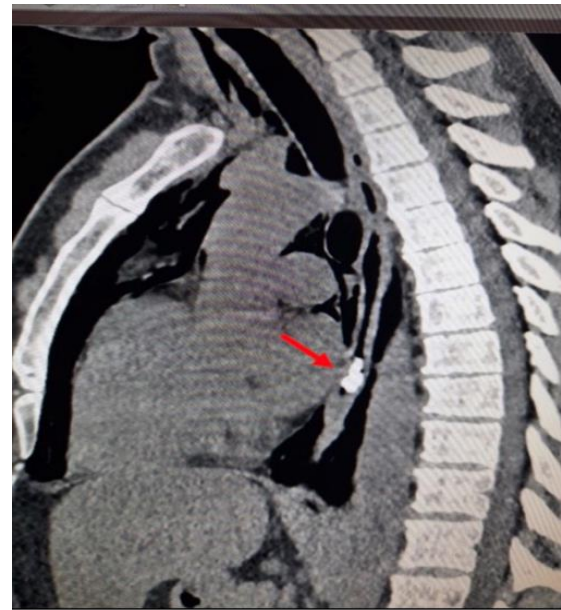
A lateral aspect of one of our CT scans denoting a hyperdense object at the distal end of the esophagus.
